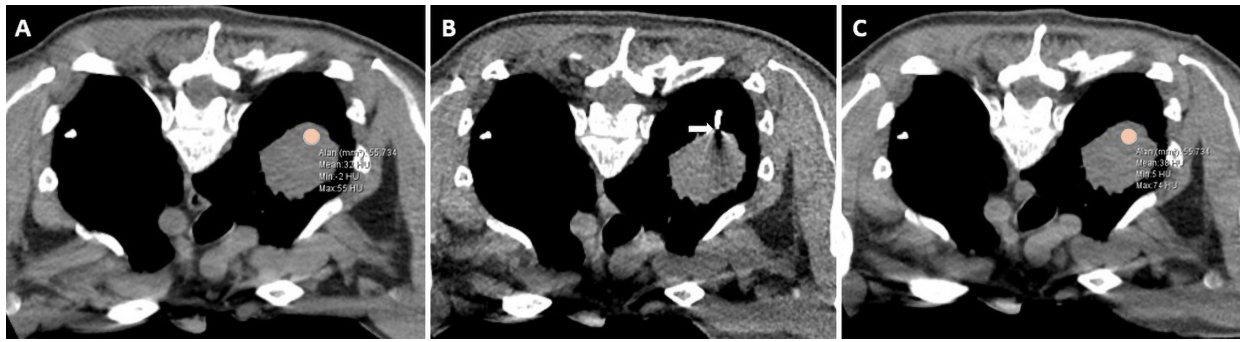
Representative axial CT images obtained before (A), during (B), and after (C) CT-guided core needle biopsy of a thoracic lesion. (A) Pre-biopsy image showing the circular ROI (area = 55.7 mm², mean = 33 HU). (B) Intra-procedural image demonstrating coaxial needle placement within the lesion (arrow). (C) Post-biopsy image at the same slice level showing the anatomically matched ROI (area = 55.7 mm², mean = 38 HU). ROI, region of interest; HU, Hounsfield unit.
